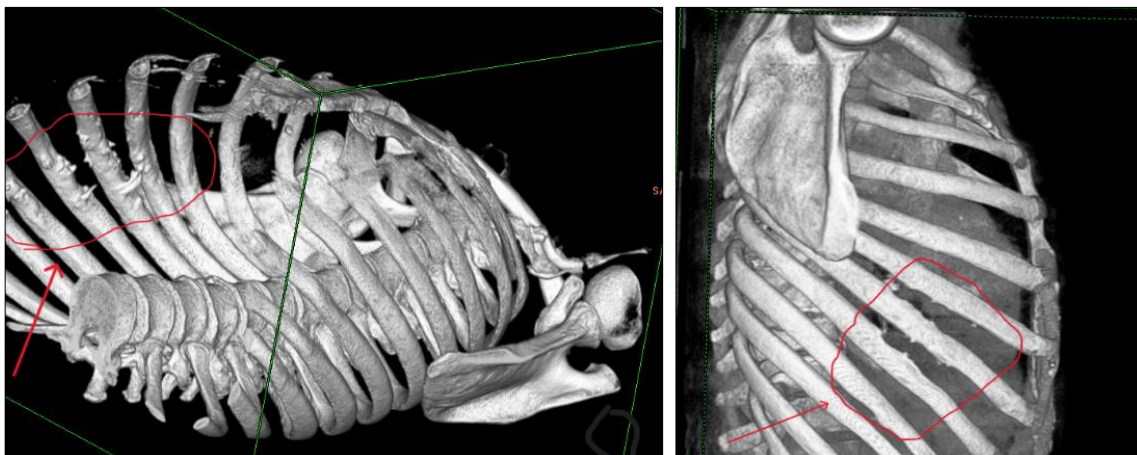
CT scan (3D reconstruction): osteolytic process of the middle arches from the 5th to the 8th rib on the right side
